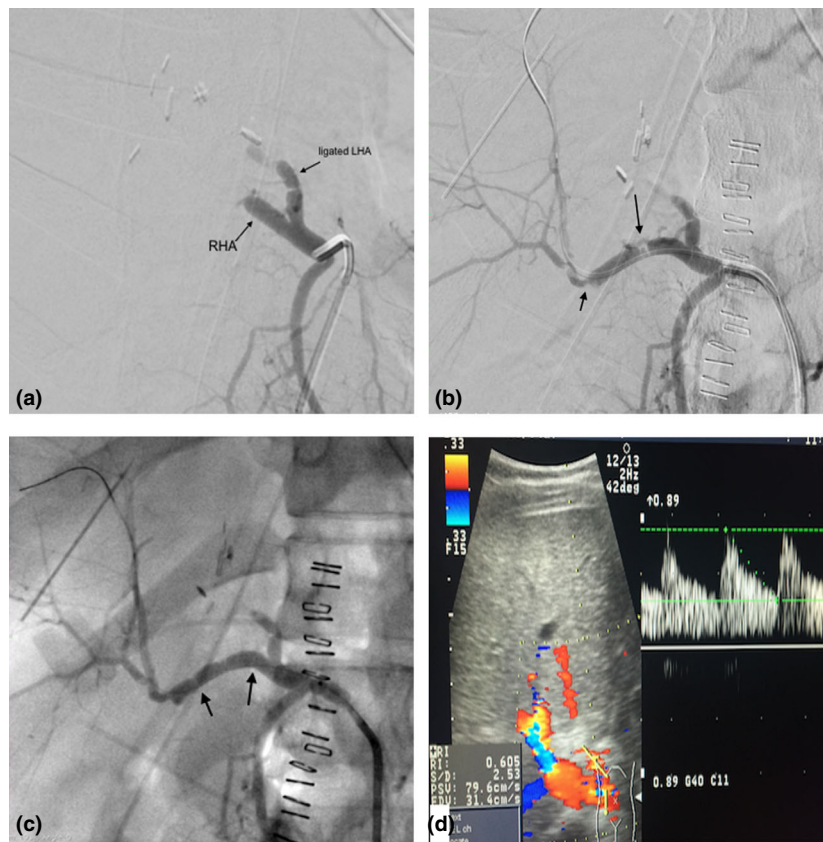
A 35-year-old LDLT recipient with shooting liver enzymes and DUS evidence of hepatic artery thrombosis on day 2 post-transplant: (a) Digital Subtraction Angiography (DSA) image showing thrombosed RHA and ligated LHA stump. (b) Hepatic angiography image, after a bolus dose of 8 mg tPA, showing successful thrombus re-canalization and a significant stricture at the proximal RHA 'probably secondary to clamp injury' (*long arrow*). The arterial anastomosis shows size mismatch between the recipient RHA & the graft artery (4mm/1.9mm), with a mild anastomotic stricture (*short arrow*). (c) Hepatic angiography image after deployment of a 4-mm balloon-expandable stent across the proximal RHA stricture and dilatation of the anastomosis using a 2-mm balloon. (d) Doppler ultrasound image 2 days later showing patent hepatic artery with normal waveform. 'LDLT: Living-Donor Liver Transplantation; DUS: Doppler Ultrasound Scanning; RHA: Right Hepatic Artery; LHA: Left Hepatic Artery; tPA: Tissue Plasminogen Activator'
